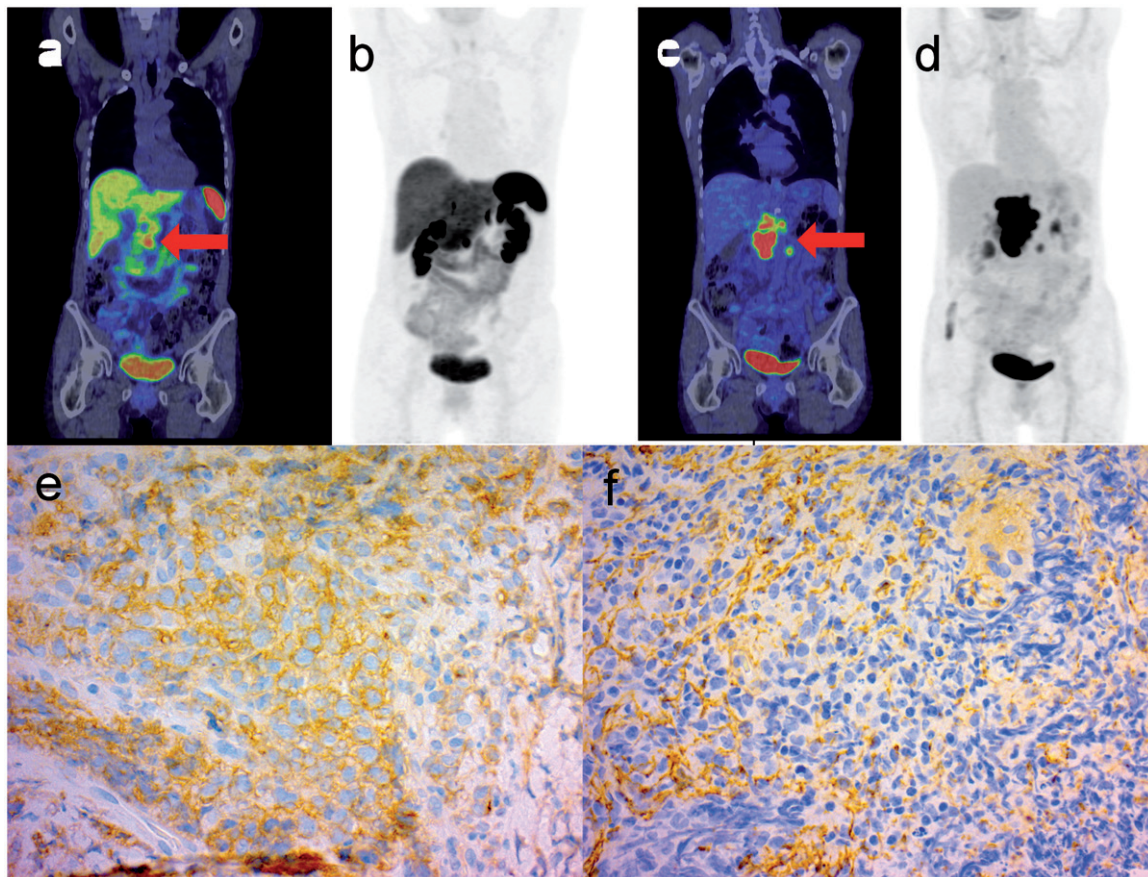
^{68}Ga -DOTANOC PET/CT (a) and maximum intensity projection (MIP) (b) images with corresponding FDG PET/CT images (c, d) of a patient with DLBCL in the pancreas mimicking NET. The lymphomatous tumor in the head of the pancreas is indicated with an arrowhead. Note that FDG PET/CT was performed six months after the first scan, and progression of lymphoma while the patient was on octreotide treatment is evident. IHC of subtype 2 (e) is positive for the malignant cells, while IHC of subtype 3 (f) shows immunopositivity only in endothelial and connective tissue.
